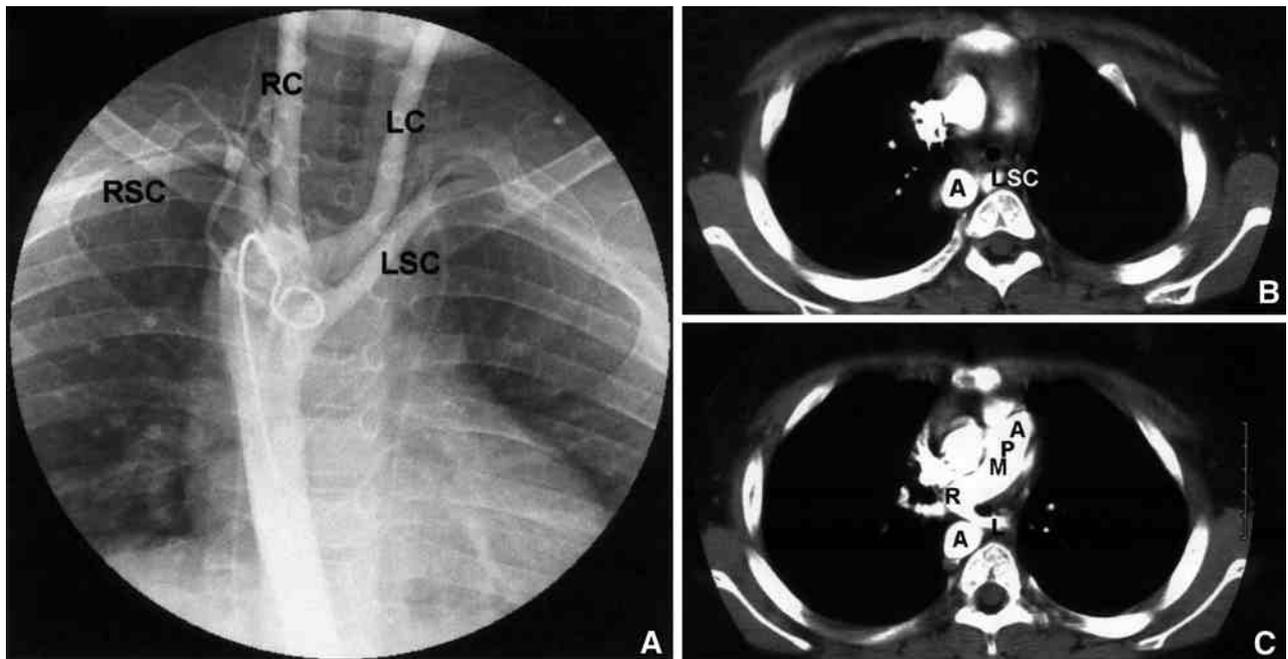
A: Aortogram shows right aortic arch, right descending aorta, and aberrant left subclavian artery course. The sequence of brachiocephalic arteries are left carotid (LC), right carotid (RC), right subclavian (RSC), and retroesophageal left subclavian (LSC). B: Computerized tomogram of chest shows complete cartilaginous ring as a cause of tracheal narrowing in front of aberrant left subclavian artery (LSC) arising from the left side of descending aorta (A). C: Chest CT shows that left pulmonary artery (L) arises from right pulmonary artery (R), forming a vascular sling that compresses the trachea.
